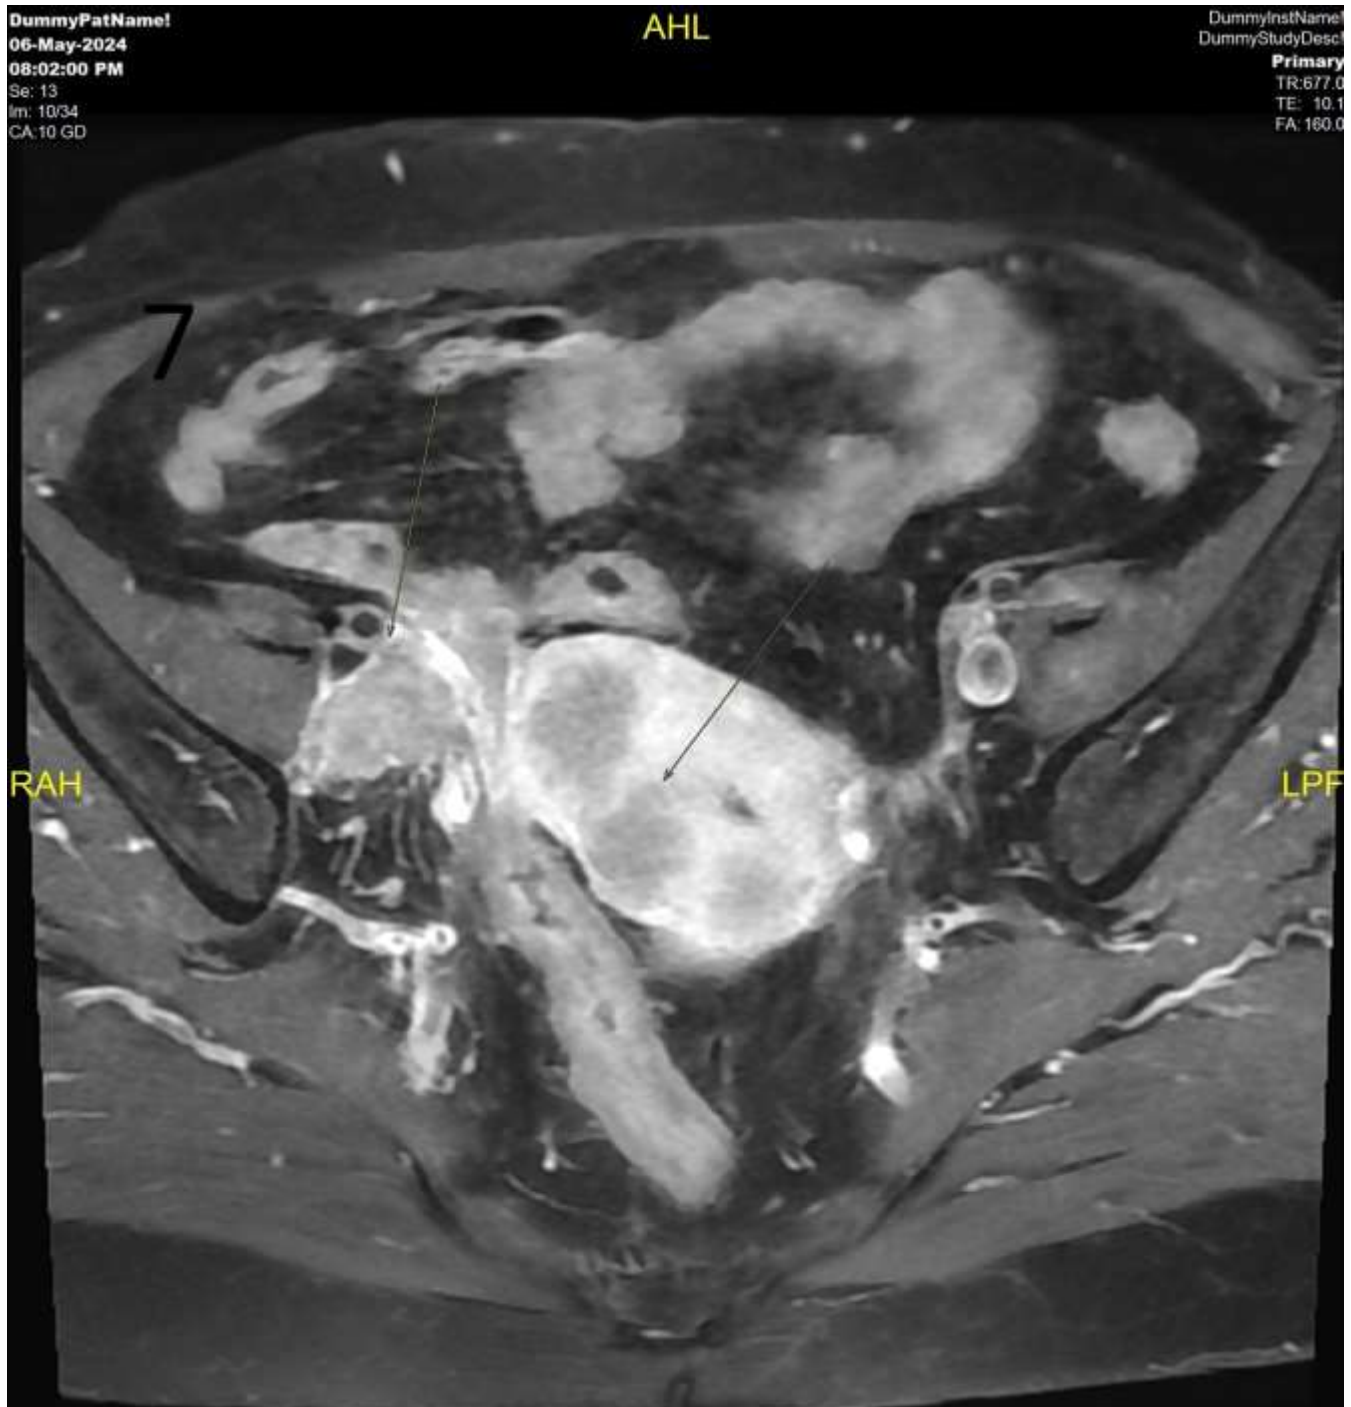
MRI pelvis dated 05/2024 (for response evaluation) in axial view post contrast T1 sequence shows interval increase in the size of heterogeneously enhancing metastatic node seen in the right external iliac region and new onset few well defined altered signal intensity heterogeneously enhancing lesions involving the myometrium of the uterus.
